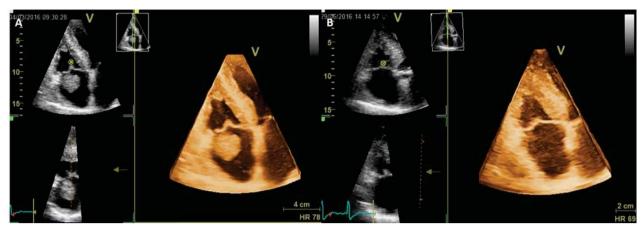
3D transthoracic echocardiography volume data – acquisition from apical 4-chamber view - at the initial presentation (A) and two months later (B) showing complete disappearance of thrombus.
